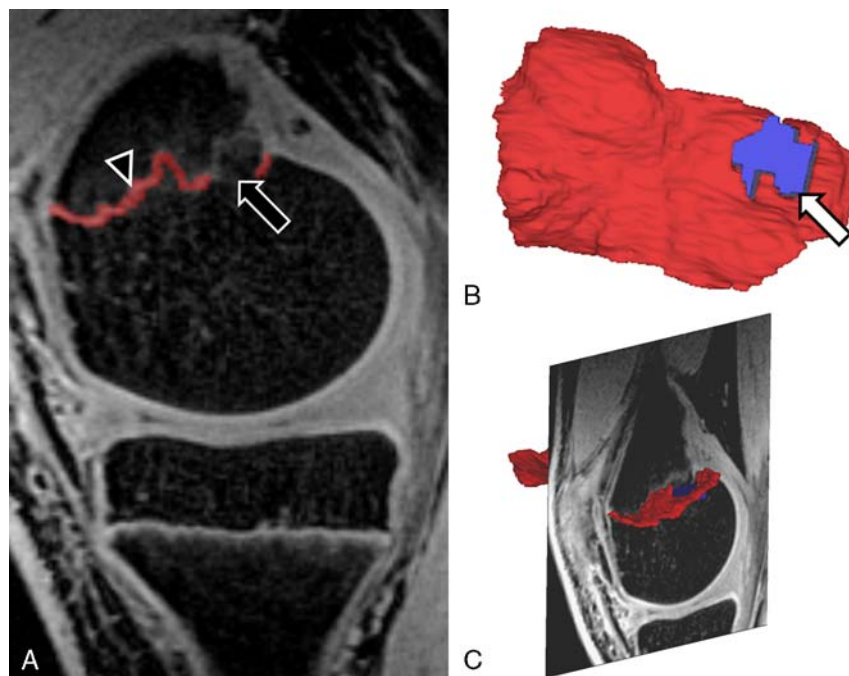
Three-dimensional physal segmentation in a 15-year-old adolescent with growth arrest following a Salter-Harris II fracture of the distal femur. A Initial segmentation (black arrowhead) of the 3-dimensional spoiled gradient recalled echo sequences sagittal magnetic resonance imaging showing a physal bar (black arrow). B, Three-dimensional physal map demonstrating the peripheral location, small size, and rounded shape of the physal bar relative to the uninjured physis (white arrow). C, Physal map superimposed on the source image.
